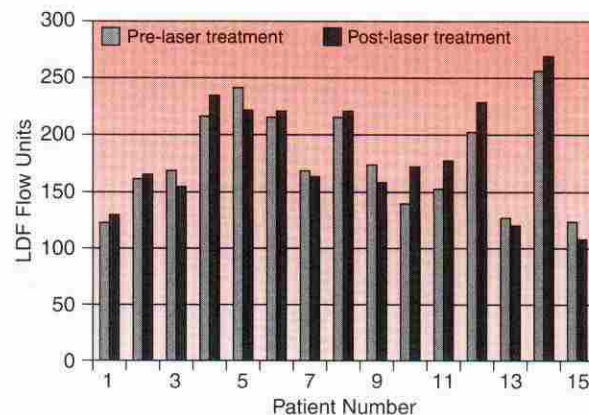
Laser Doppler flowmetry (LDF).
